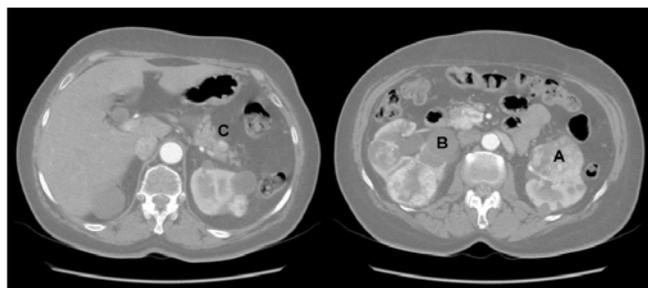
CT showed masses in both kidneys suspected to be RCC (A), the multiple cysts (B) and irregular polycyclic lesion in the pancreatic head, suspected to be NET or RCC metastases to the pancreas (C).
